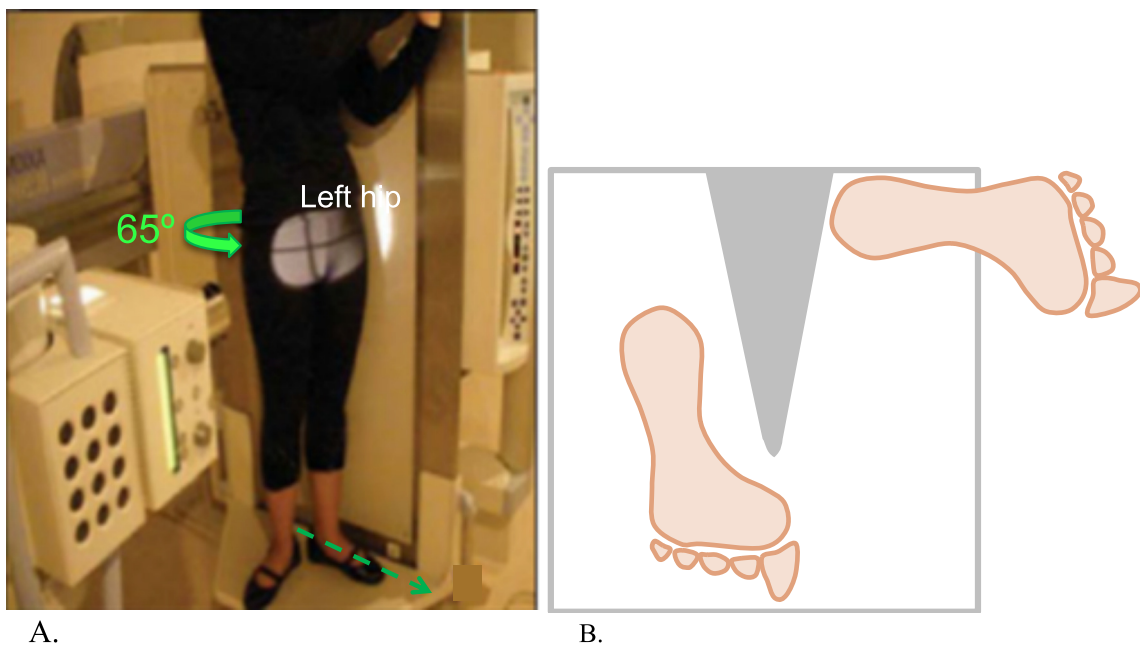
Standing oblique (false profile of Lequesne) view. Subject stands on Fixed Flexion Frame facing X-ray tube turned 65° towards the hip of interest, in this example the left hip (A), with the ipsilateral foot parallel to posterior wall of the frame and detector (B).
